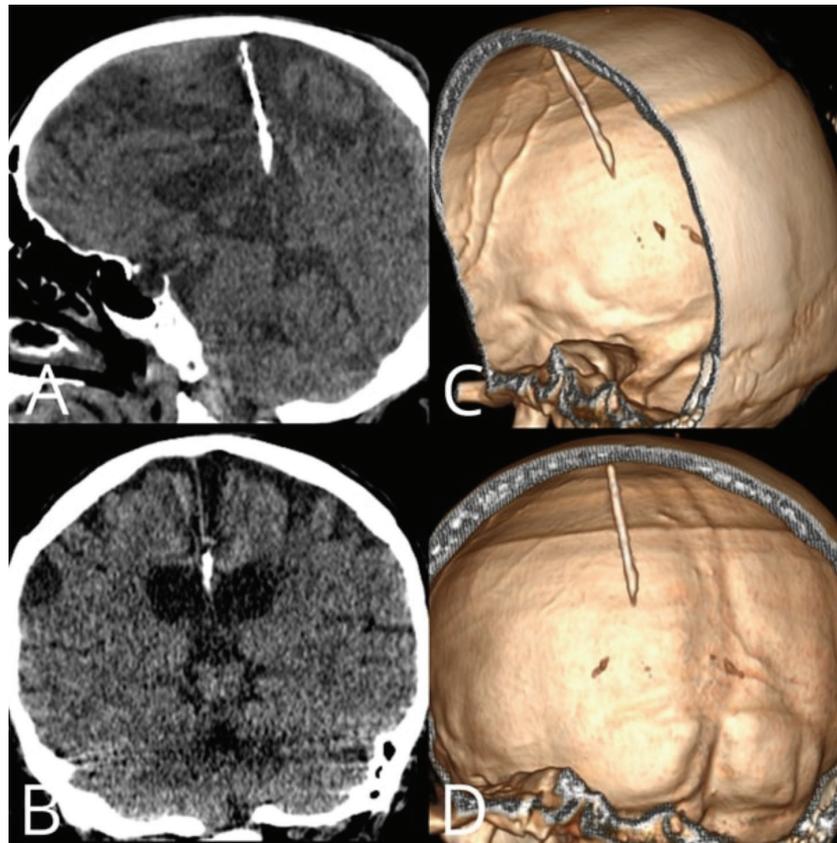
CT scan reveals intracranial foreign body through midline beside falx approximately 4 cm long with regular borders and sharp tip
